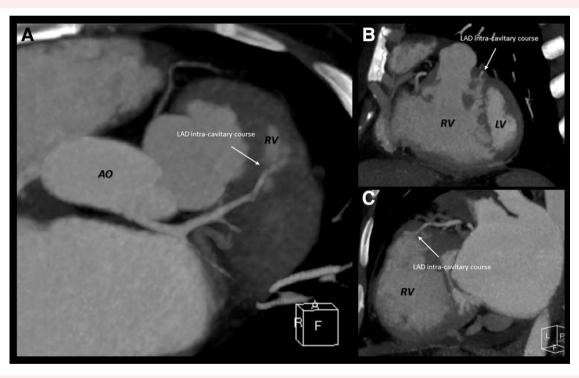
MDCT double oblique axial (A), coronal (B), and sagittal (C) views showing the intra-cavitary course of the left anterior descending artery within the right ventricle cavity. MDCT, Multi-detector computed tomography; LV: left ventricle.
